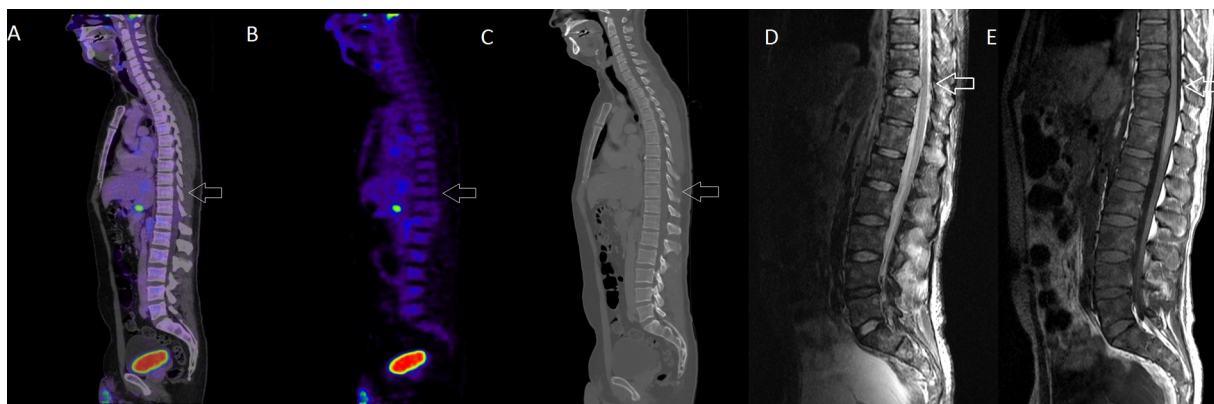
A 46 year old man was diagnosed with cardiac cancer (subcardial grade III). An initial FDG-PET/CT scan showed no bone metastases in the spine (A: PET/CT sagittal fused image; B PET sagittal view; C: CT sagittal view). 3 months later, persisting back pain gave rise to an MRI scan showing disseminated cancer with a biopsy-proven bone metastasis in Th10 (arrow) with posterior soft tissue bulging and compression of the medulla (D: Sagittal T2 Stir TR/TE 3500/38,496 ms E: sagittal T1 TR/TE 350/12,832 ms).
